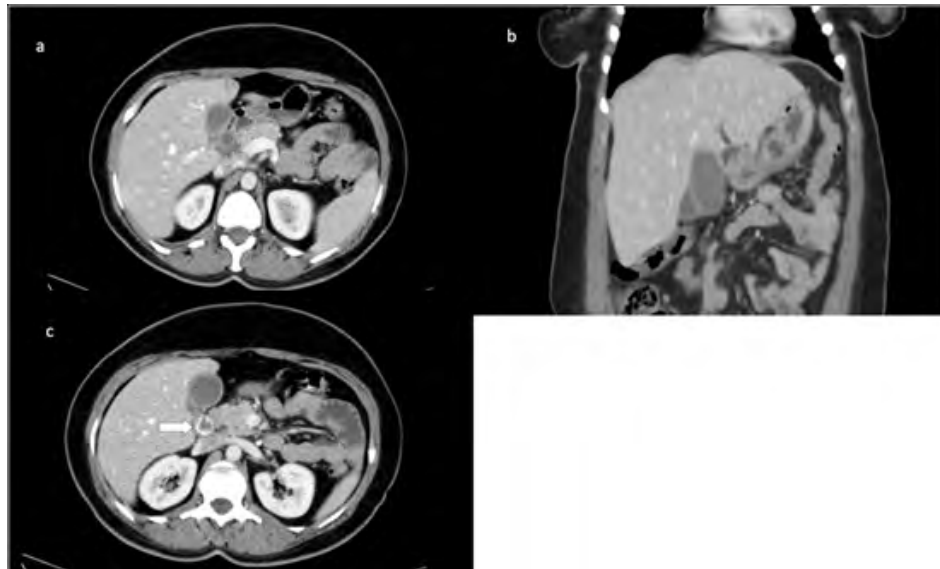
Computed tomography showing preoperative gallbladder duplication a: axial section b: coronal section c: gallbladder stone marked with arrow
